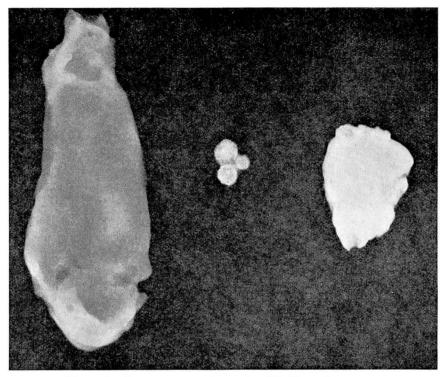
Roentgenogram of opened gallbladder and contents.
